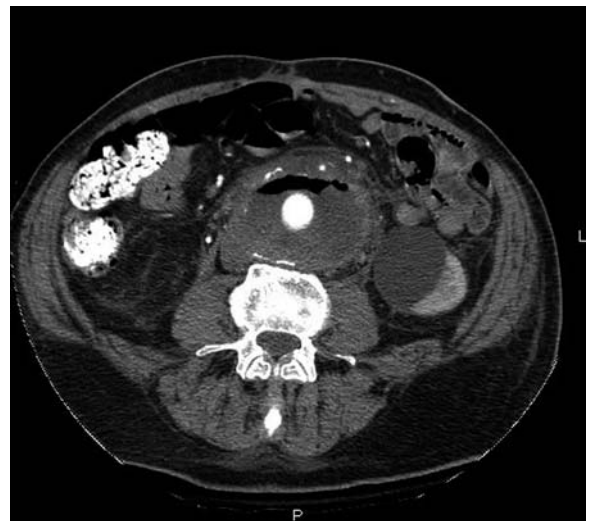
CT scan of a patient 33 months following emergent aortic graft placement for a ruptured abdominal aortic aneurysm. The graft is surrounded in fluid with a gas pocket located anteriorly. A large left renal cyst is also seen. At operation an aorto-enteric fistula was identified. Operative cultures grew *Enterococcus* species, *K. pneumoniae*, and *C. albicans*
